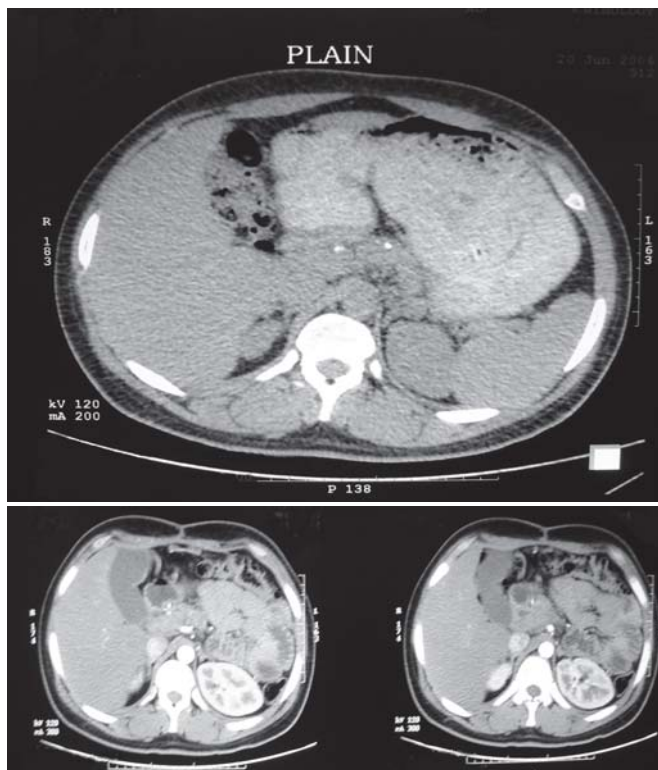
Abdominal CT scan after the first operation
